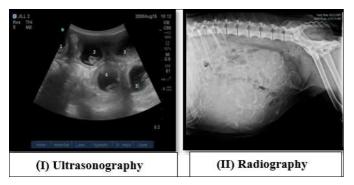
Ultrasonography and Radiography give definitive diagnosis.
